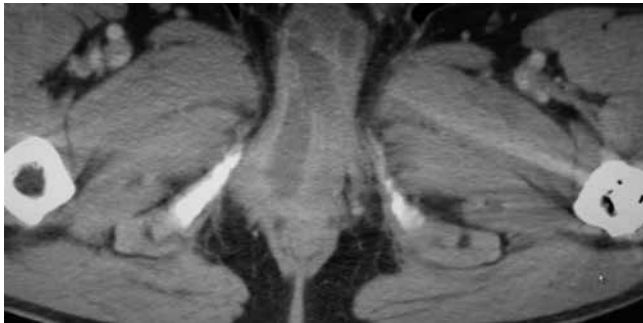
CT scan with fluid collection involving the bilateral cavernosal bodies.
